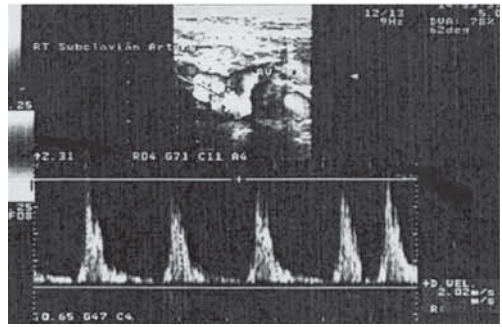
Duplex ultrasound of the right subclavian artery, proximal to the vertebral artery origin: there is a significantly higher peak systolic velocity (231cm/s), with flow turbulence (filled systolic window), indicating stenosis.
